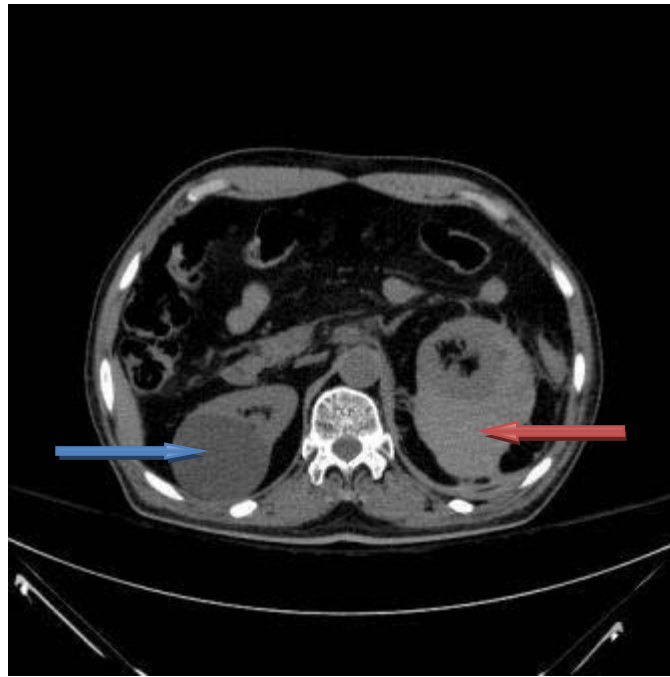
plain CT scan showing the left perinephric hematoma (red arrow) and the right renal cyst (blue arrow)
